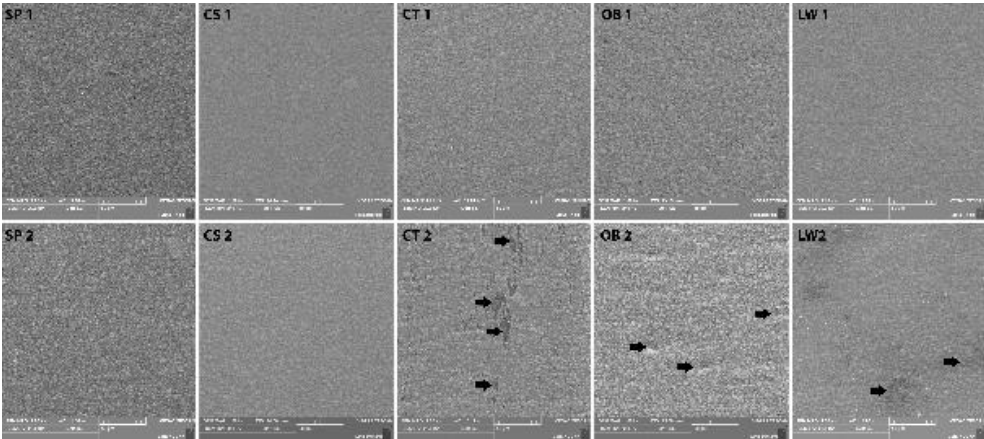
Representative SEM images of the Lava Ultimate material, with a magnification of $\times 1000$, from a before (1) and after brushing (2) using sensitivity (SP and CS), regular (CT), or whitening (OB and LW) toothpastes. The black arrows point to the cracks or scratches caused by brushing.
